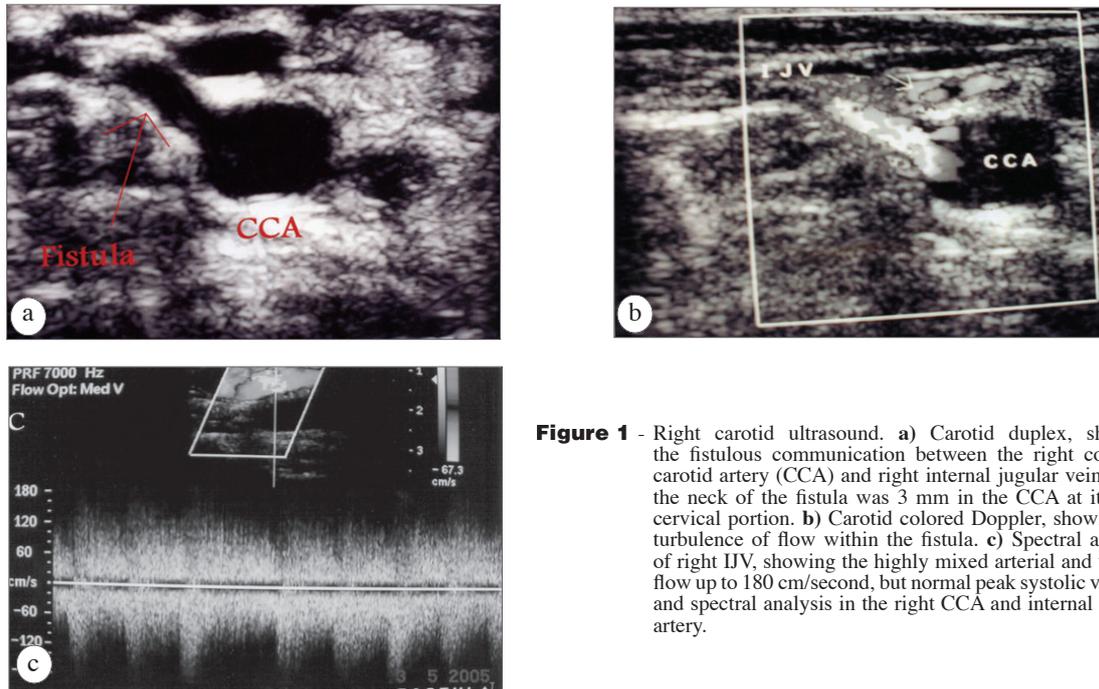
Right carotid ultrasound. a) Carotid duplex, showing the fistulous communication between the right common carotid artery (CCA) and right internal jugular vein (IJV), the neck of the fistula was 3 mm in the CCA at its mid-cervical portion. b) Carotid colored Doppler, showing the turbulence of flow within the fistula. c) Spectral analysis of right IJV, showing the highly mixed arterial and venous flow up to 180 cm/second, but normal peak systolic velocity and spectral analysis in the right CCA and internal carotid artery.
